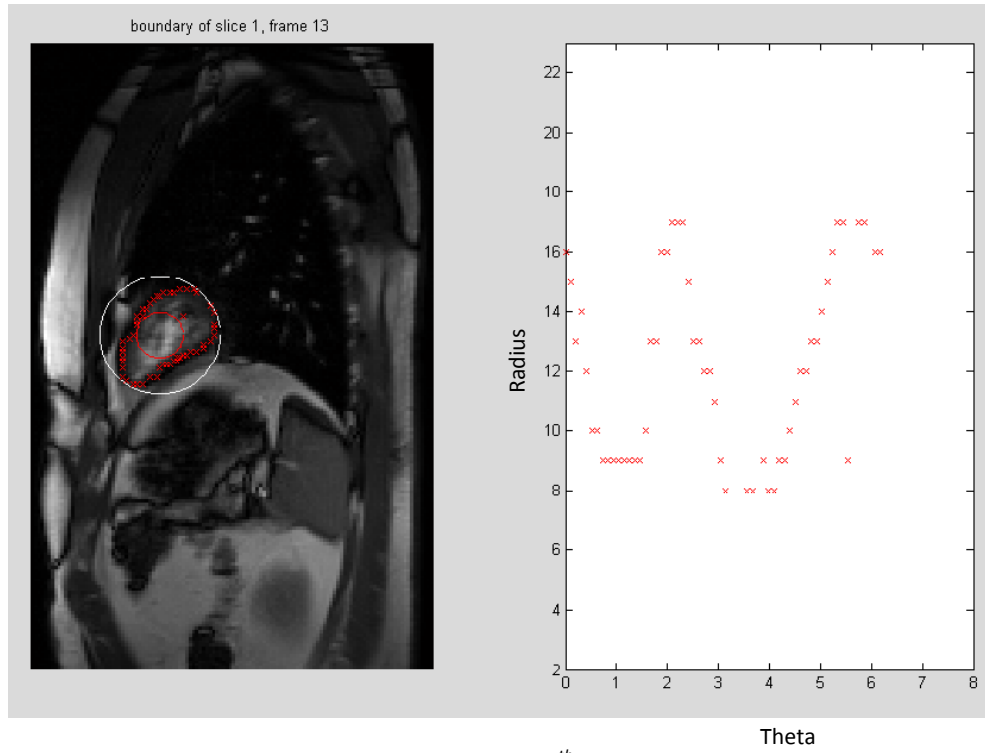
Points found in the first slice and 13th frame. In the left, on the real MRI.
